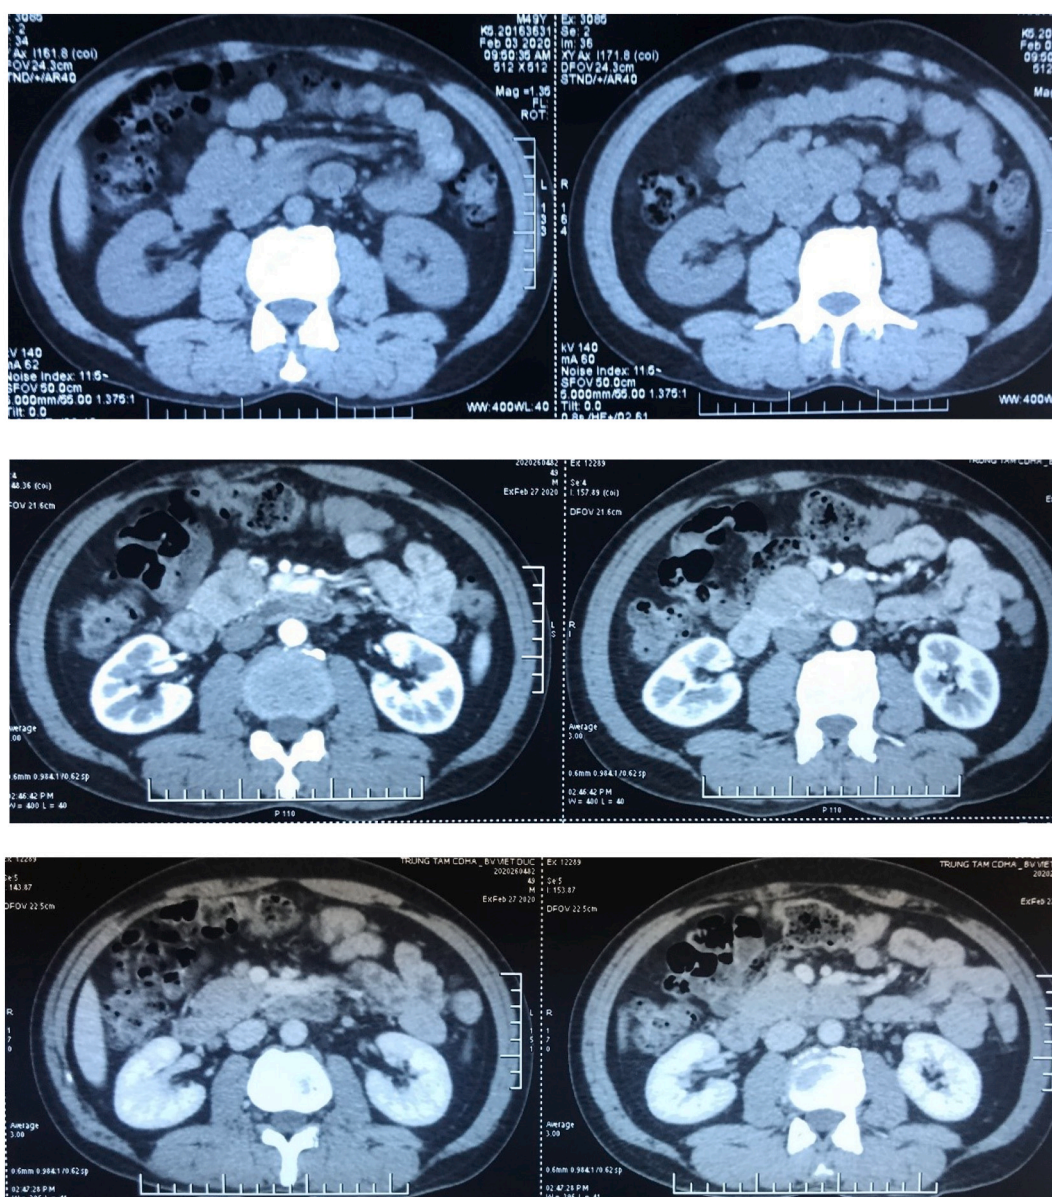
Computed tomography findings. Contrast-enhanced computed tomography (CT) revealed three lymphatic neoplasms measuring approximately $28 \times 22 \times 30$ mm, $27 \times 33 \times 38$ mm and $22 \times 35 \times 48$ mm in size in the pancreatic-duodenal junction and retroperitoneal para-aortic. a. The non-contrast phase. b. The arterial phase. c. The portal phase.
